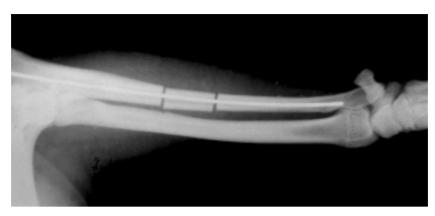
A radiograph showing the study model. An autograft transplant in the defect fixed with an intramedullary Kirschner wire.
